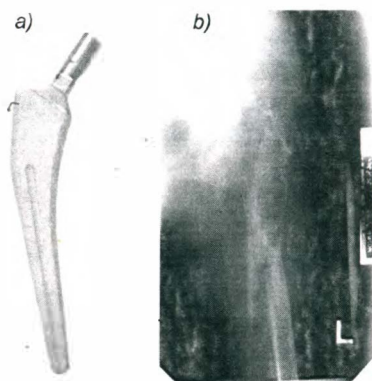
a) Traditional long-stem hip endoprosthesis; b) the roentgenogram showing the destruction in femoral bone with bone resorption caused by the stress shielding phenomenon
